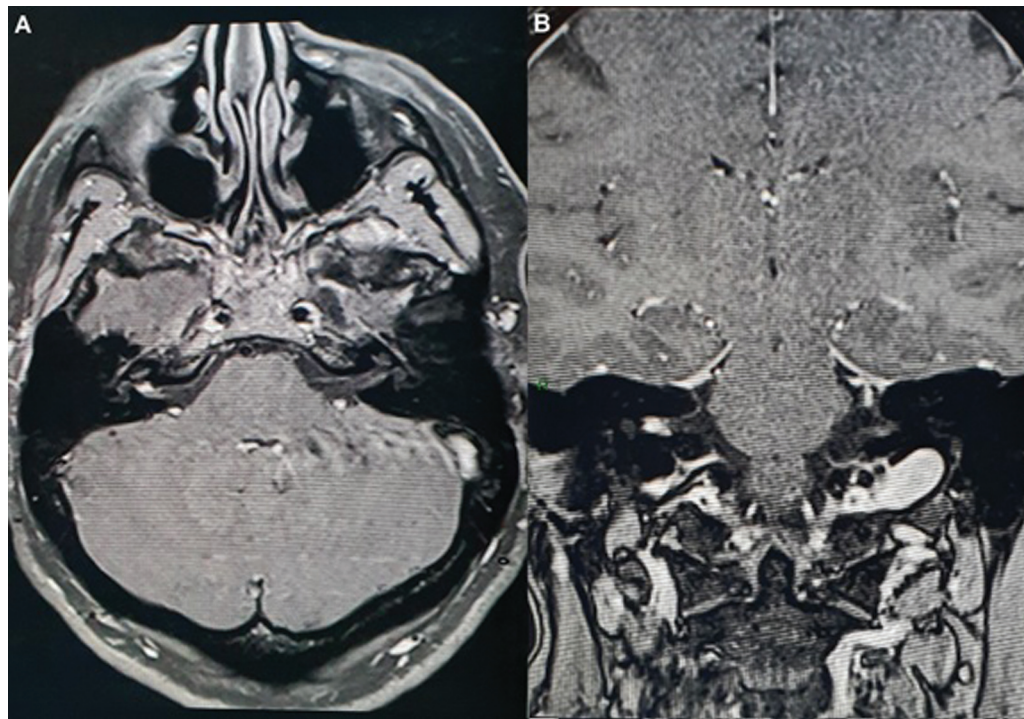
T1-weighted gadolinium-enhanced MRI showing heterogeneous gadolinium-enhanced lesion in the distal portion of the internal acoustic canal. (A) Axial image. (B) Coronal image. MRI, magnetic resonance imaging.
